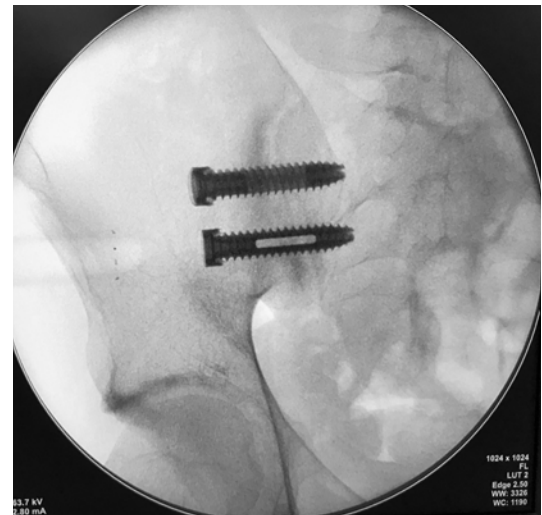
Right side SIJ fixation, AP radiographic view: the lower screw inserted at the level of S2 shows fenestration, to facilitate bone integration.
